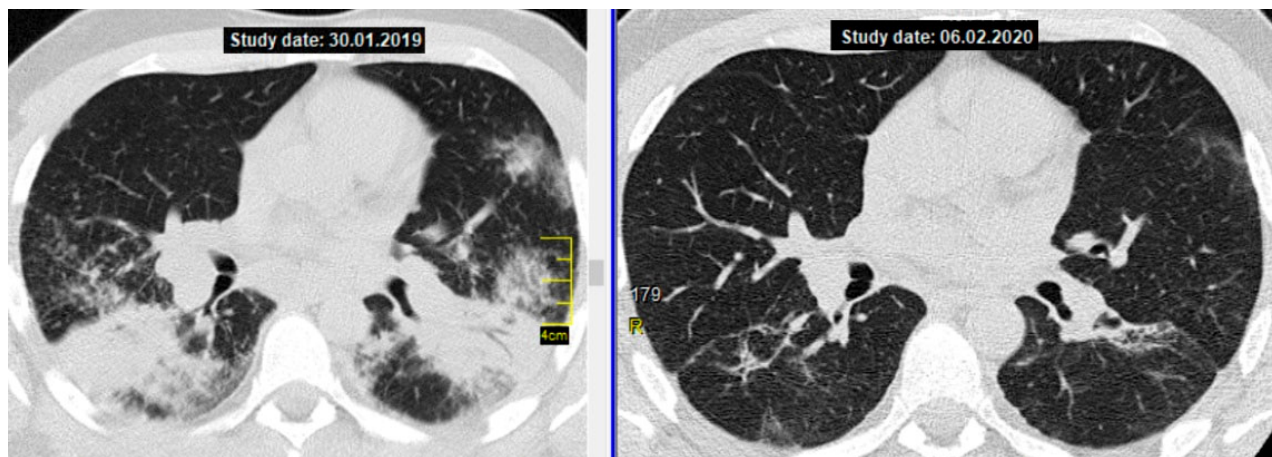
Patient S., 27 years old, pulmonary sarcoidosis, stage II; CT of TO (axial section at the level of division of the main bronchi). On the left - before treatment, on the right - at the end of treatment with MT (15 mg/week): complete regression with residual changes in the form of limited interstitial pulmonary fibrosis
